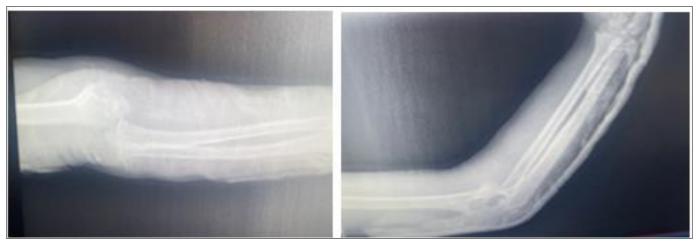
Initial X-rays taken in the emergency room.
